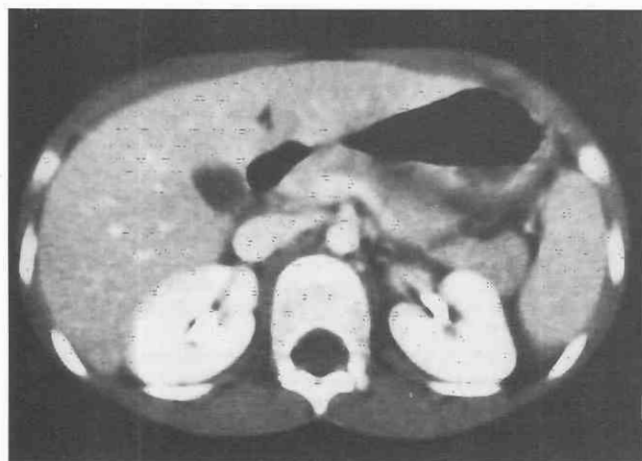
Pancreatic laceration. CT scan through the pancreas in a patient who was assaulted shows a laceration through the tail of the pancreas.
